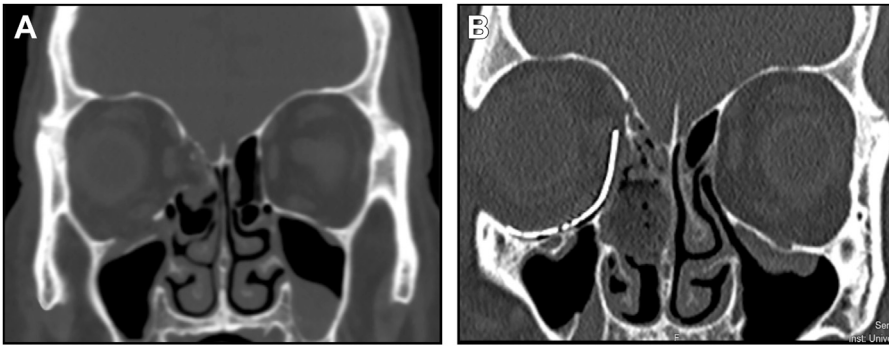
(A, B) Preoperative and postoperative 1-mm thin-slice CT on coronal view demonstrating orbital floor and medial wall reconstruction with restoration of orbital volume after a naso-orbital-ethmoid fracture. The senior author used a titanium mesh PSI, design specifications detailed in Fig. 6. Concurrent limited maxillary antrostomy, middle turbinectomy, and ethmoidectomy with reduction of encephalocele and packing in place in right nasal cavity.
